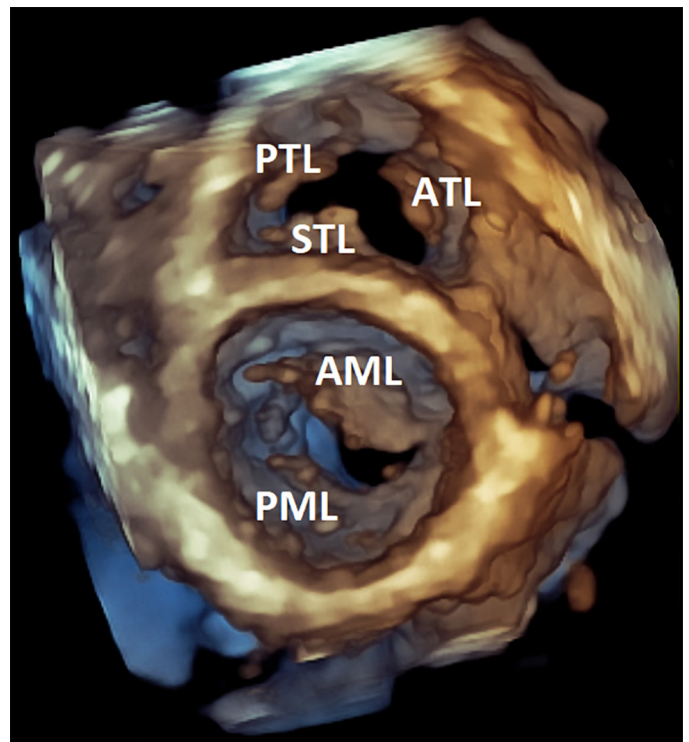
Representative volume-rendered three-dimensional (3-D) transthoracic echocardiographic image of an athlete's heart (diastolic frame). Using an apical perspective, anterior mitral valve leaflet (AML), posterior mitral valve leaflet (PML), septal tricuspid valve leaflet (STL), posterior tricuspid valve leaflet (PTL), and anterior tricuspid valve leaflet (ATL) are visible. The generally excellent transthoracic windows of athletes represented the basis for our advanced mitral and tricuspid valve measurements.
